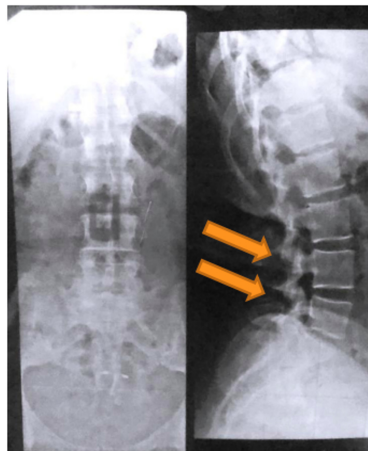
Lumbar X-ray, Lumbalgia. The arrows indicate the place marked by the traumatologist of low back pain L3, L4, S1, the same place shown in the thermography.
